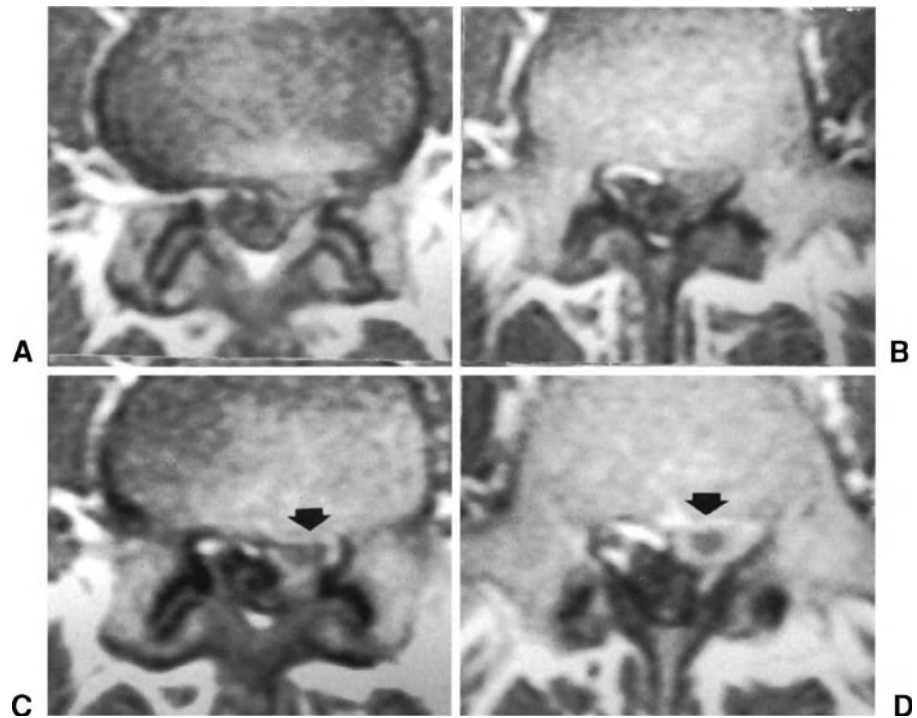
Left L4-L5 extruded disc herniation. Spin-echo T1-weighted MR images without contrast medium at the level of the disc (A) and the proximal portion of the L5 pedicle (B) and after administration of gadolinium (C) and (D) at the same levels. On the images obtained after injection of gadolinium, signal hyperintensity is observed around the herniated tissue (arrows), due to the presence of granulation tissue.
